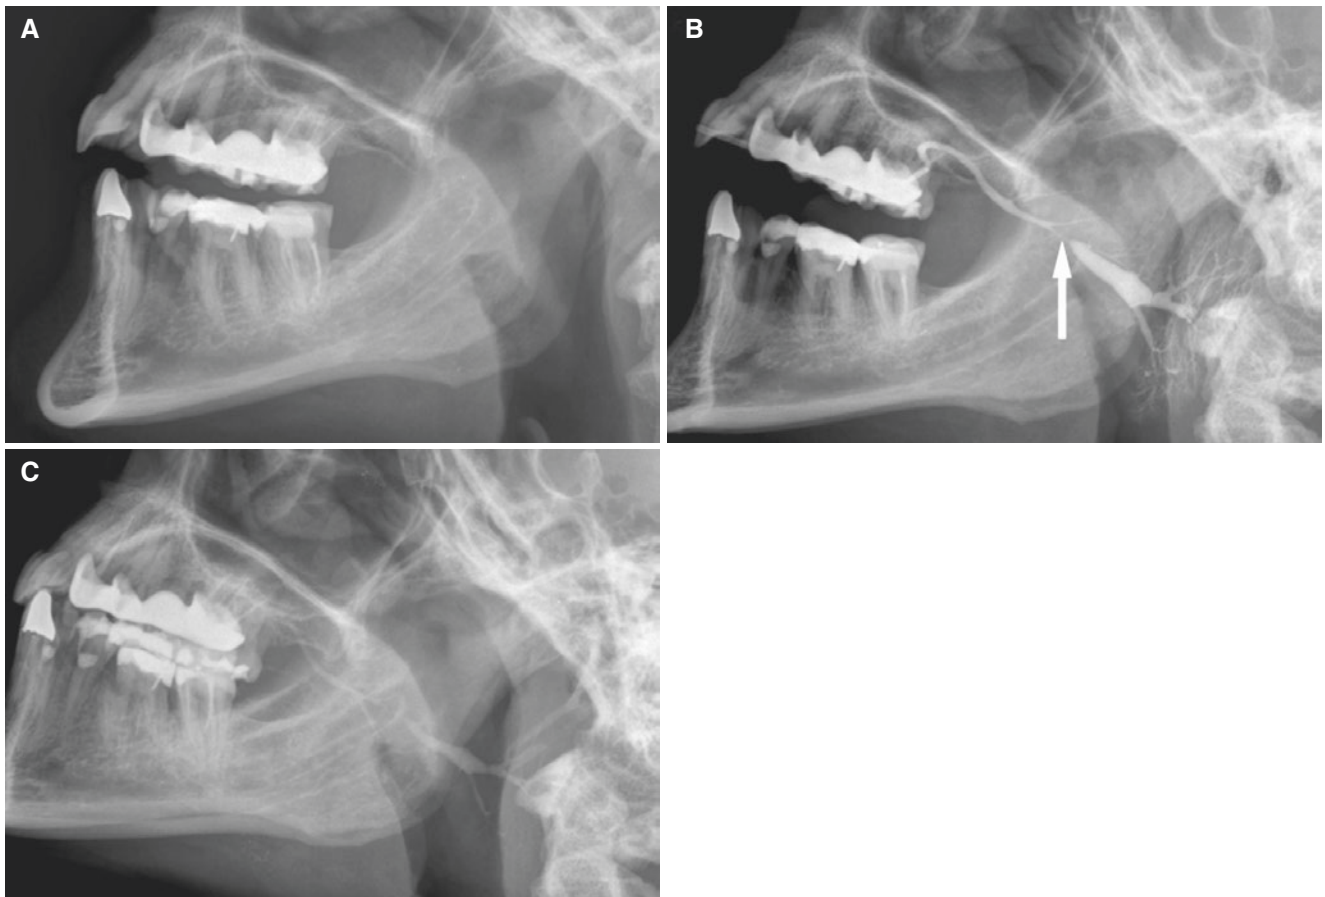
Parotid sialography; sialodochitis, normal parenchyma. (A) Side view shows no signs of stone in Stensen's duct. (B) Plain film sialography shows stricture (*arrow*) and dilatation proximal duct.
